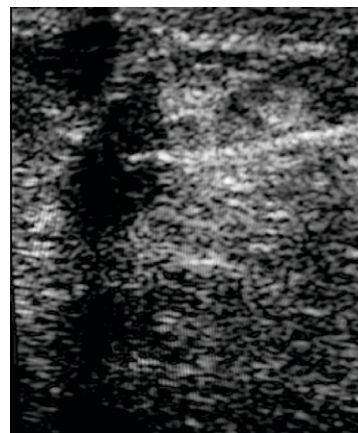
Ultrasound Guided Core Needle Biopsy Image Showing Needle Inside the Breast Lesion*
